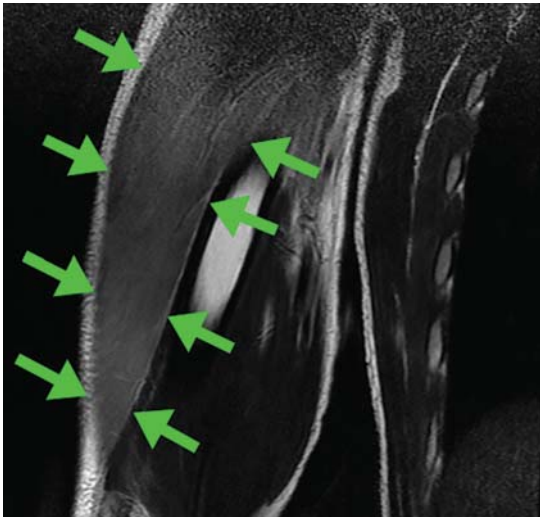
T2-weighted magnetic resonance imaging showed diffuse hyperintensity in both triceps brachii muscles (arrows).
